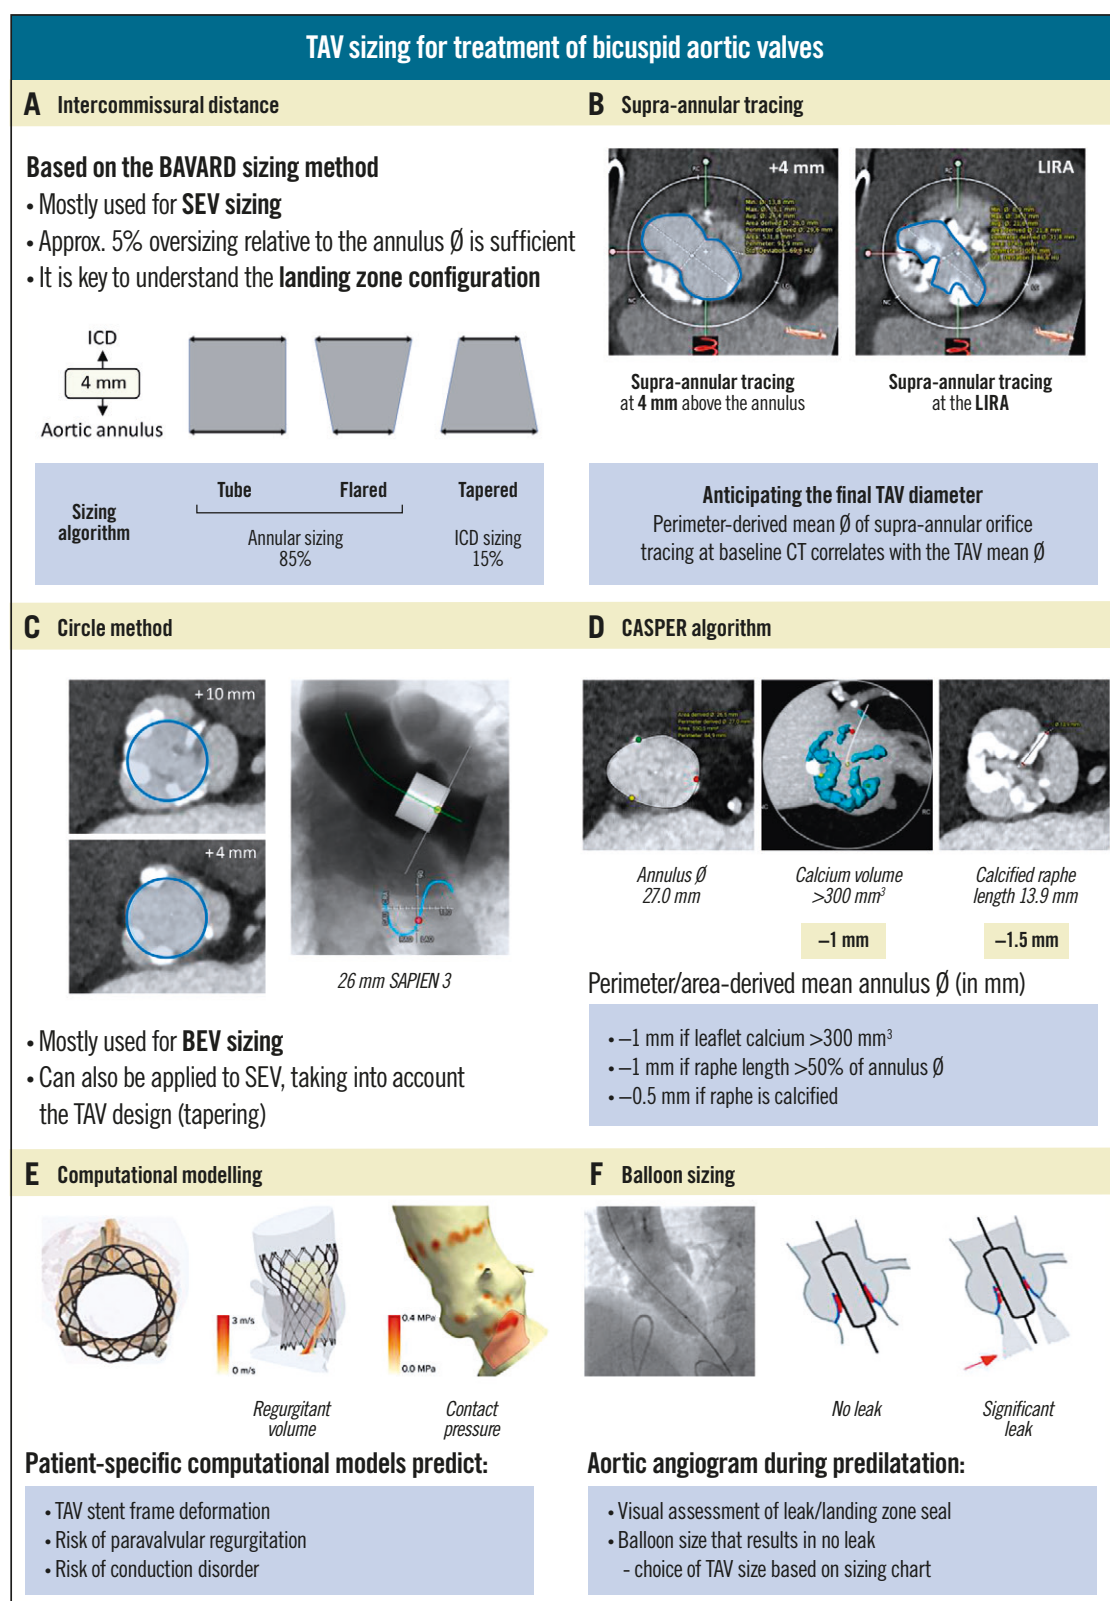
Different TAV sizing methodologies for the treatment of bicuspid aortic valves. A) Intercommissural distance, based on the BAVARD sizing method. B) Supra-annular tracing. C) Circle method. D) CASPER algorithm. E) Computational modelling. F) Balloon sizing. BAVARD: Bicuspid Aortic Valve Anatomy and Relationship with Devices; BEV: balloon-expandable valve; CASPER: Calcium Algorithm Sizing for bicusPid Evaluation with Raphe; CT: computed tomography; ICD: intercommissural distance; LIRA: Level of Implantation at the Raphe; SEV: self-expanding valve; TAV: transcatheter aortic valve
